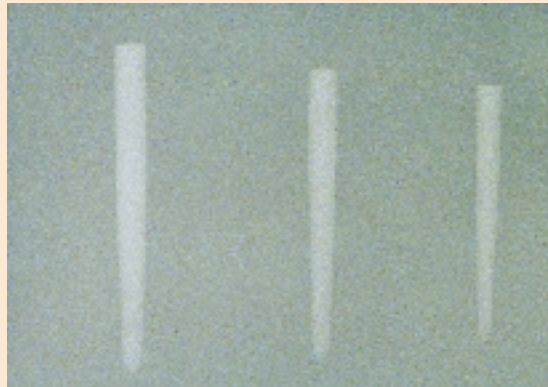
Radiograph of three different diameters of the light-transmitting Luscent Anchors™.
